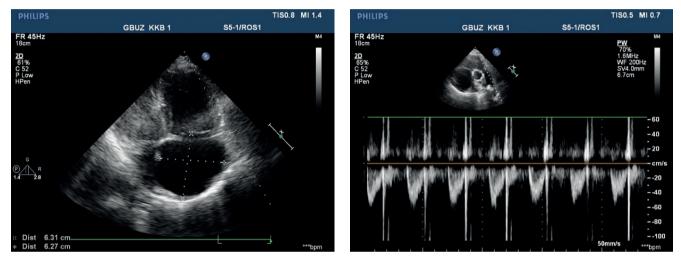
Echocardiography upon admission of 50-years-old female patient: severe PH. Severe TV regurgitation. Right heart dilation.
